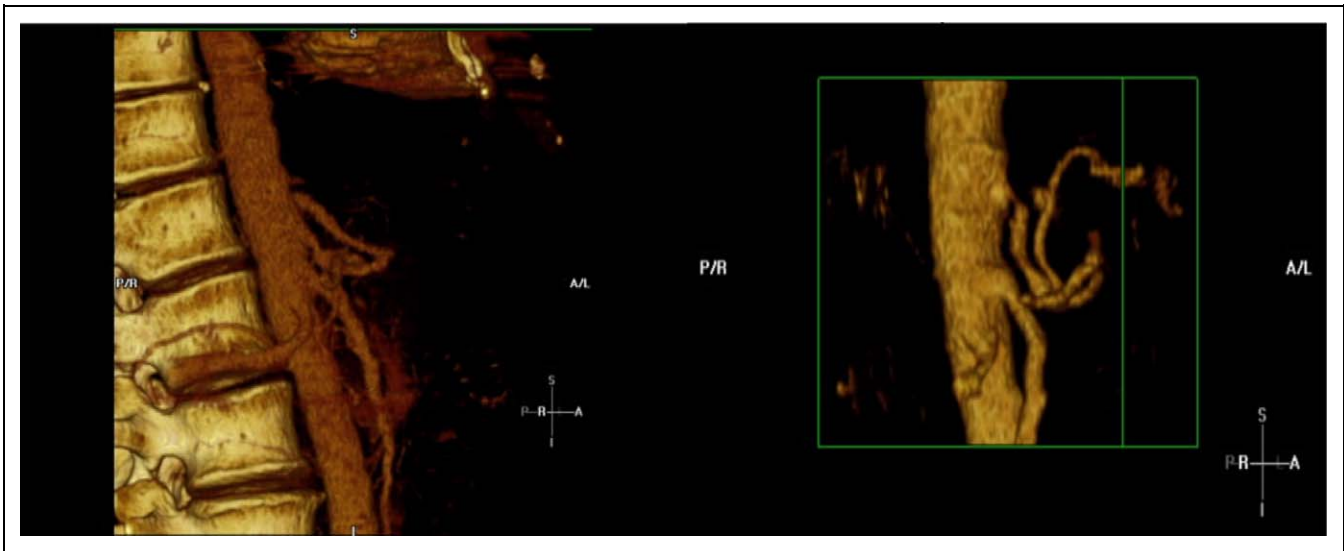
Three-dimensional multichannel computed tomographic angiography of 2 patients with postprandial epigastric pain. Both demonstrate the characteristic focal narrowing in the proximal celiac axis that has a distinct hooked appearance. Poststenotic dilatation of the artery is demonstrated.
